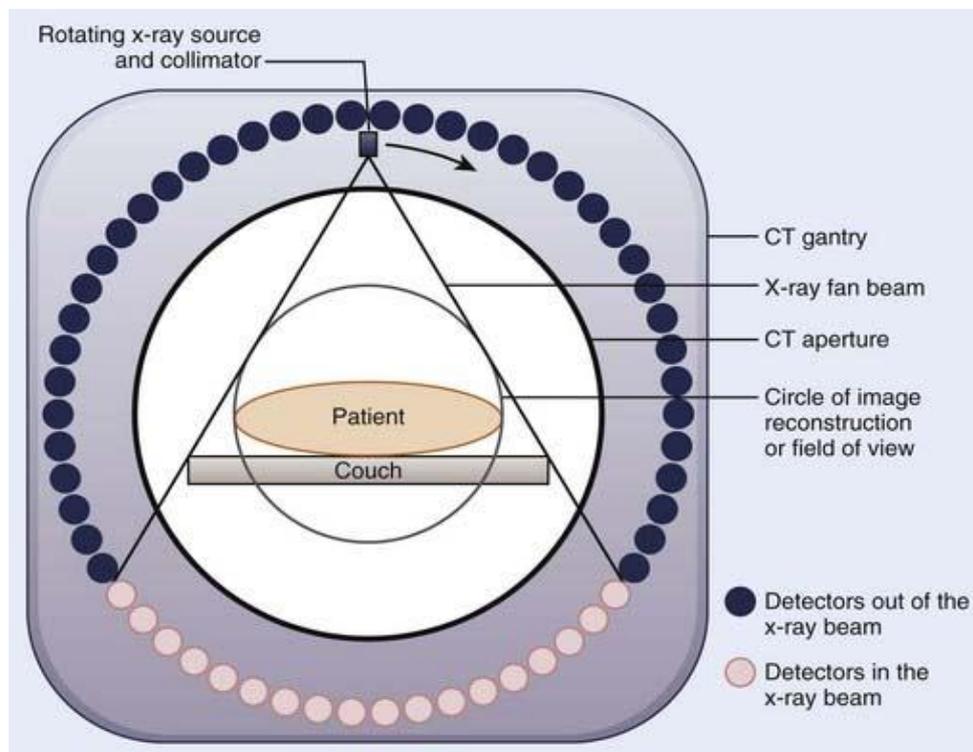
CT scanner Gantry
